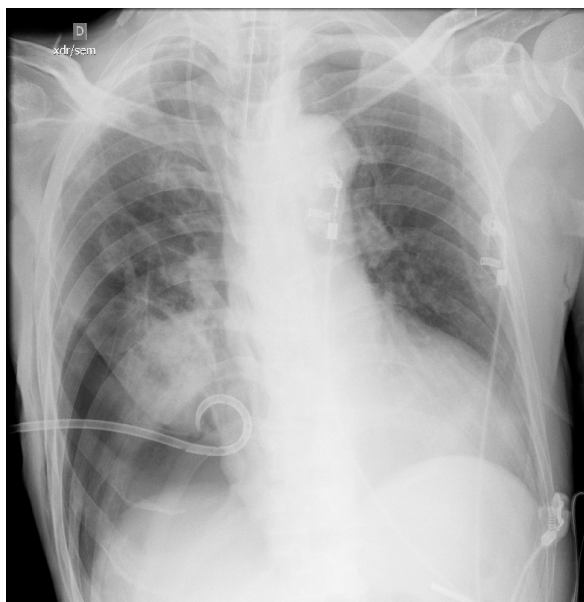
Chest X-Ray. Cardiomegaly and pulmonary condensation in the right inferior lobe.
